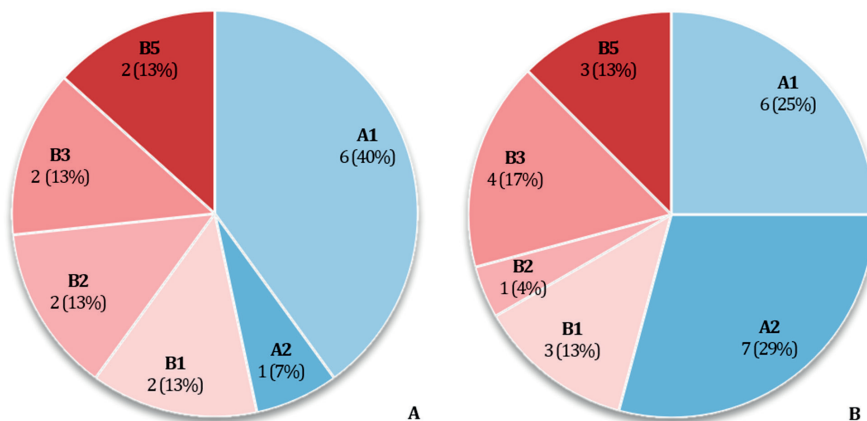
Pie chart showing the Herbert scaphoid fracture classification on CT (A) and HR-pQCT (B) ($W = 0.793$).
